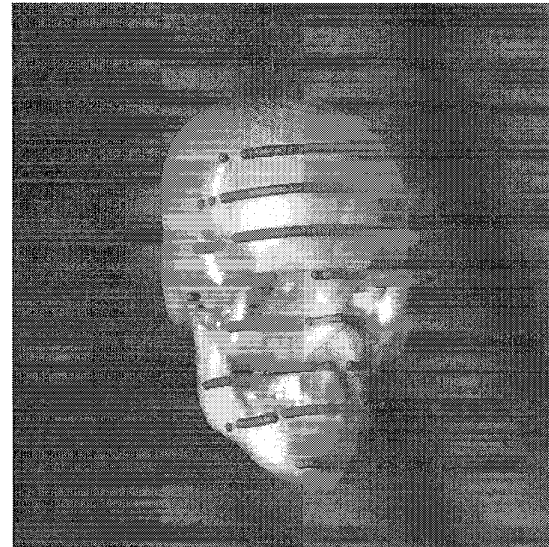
Examples of registered laser data (shown as large dots) overlaid on CT model.
